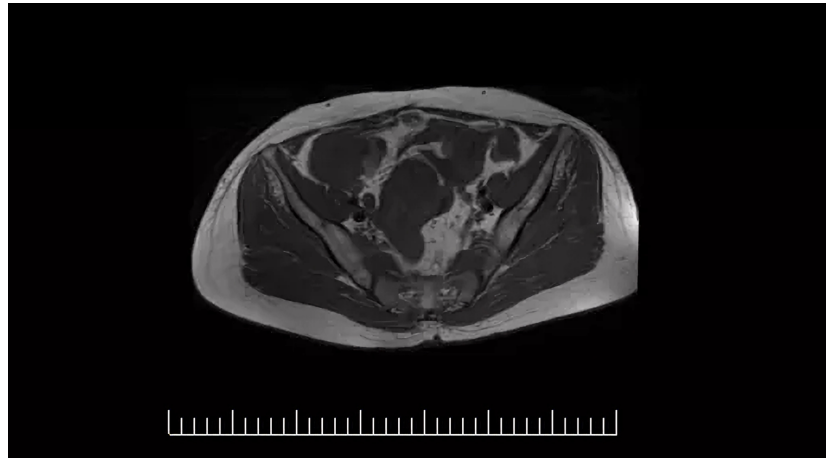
MRI Ax T1 FSE image: Strip-shaped high-signal shadows can be seen in the low-signal lesion, presenting a multilocular structure.
